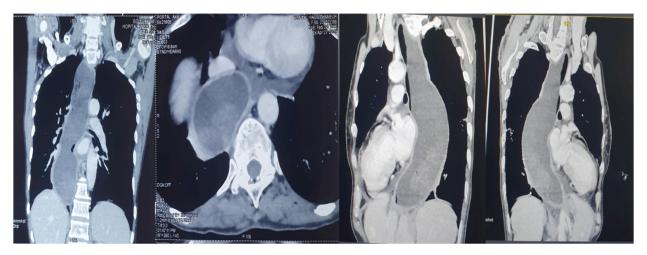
Thoraco-abdominal CT with digestive opacification showed an esophageal dilatation with stasis measuring 61 mm at most, without any image of luminal stenosis or detectable extrinsic compression. Sigmoid shape esophagus.
